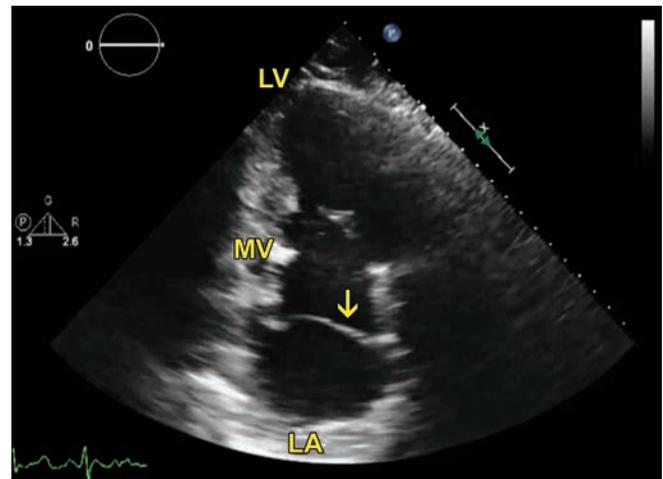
Transthoracic apical 2-chamber view. Arrow points to a linear echodensity in the left atrium.
